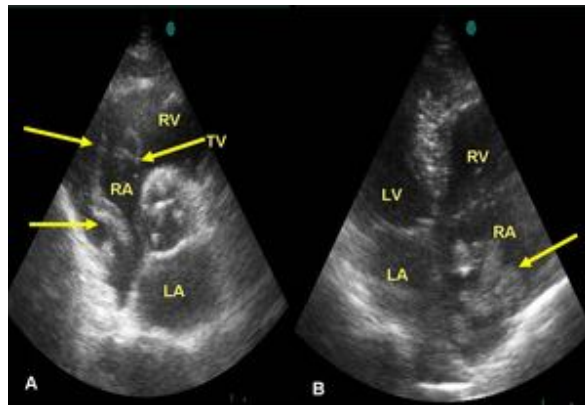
Modified short axis (1A) and Apical four-chamber (1B): Worm-like thrombus floating in the right atrium (arrows)
